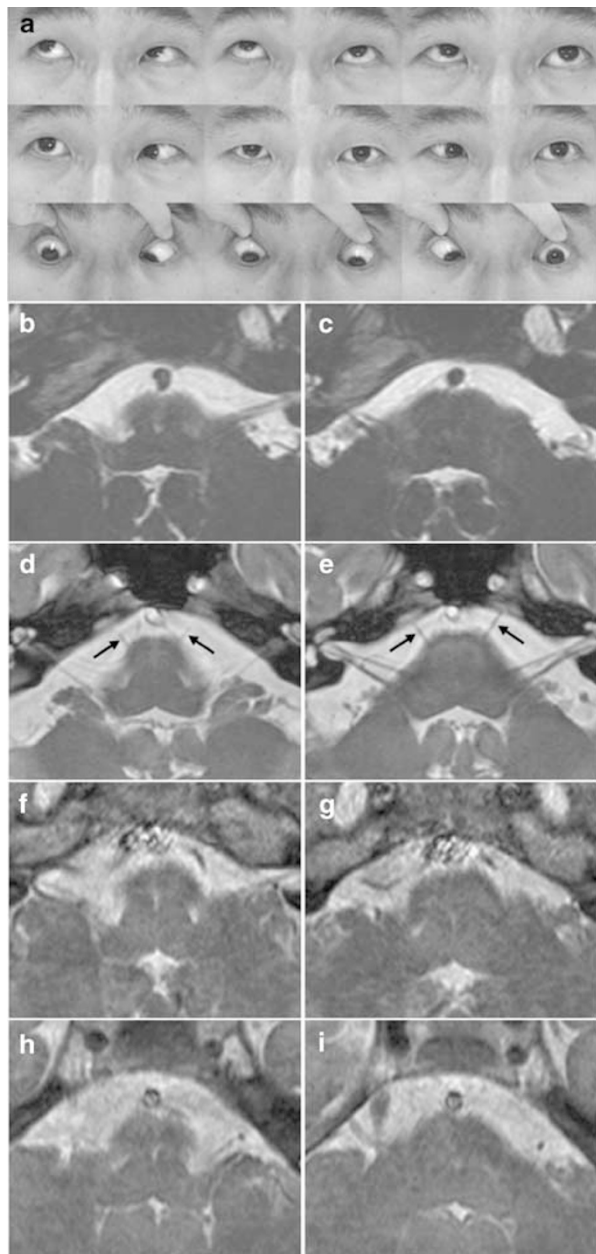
Duane's retraction syndrome type 1 in Cases 1–3. (a) In Case 1, ocular versions demonstrate bilateral abduction deficit and a small degree of narrowing of the lid fissure on adduction in both eyes. (b, c) In Case 1, right and left abducens nerves are not identified on the two axial magnetic resonance (MR) images obtained at the level of the pontomedullary junction. (d, e) Note normal abducens nerves in a normal adult. Two axial MR images show the path of the right and left abducens nerves (arrows), as linear dark structures emerging from the pontomedullary sulcus (d), coursing in the superior oblique direction toward the clivus (e). (f–i) In Case 2 (f, g) and Case 3 (h, i), right and left abducens nerves are not identified as in Case 1.
